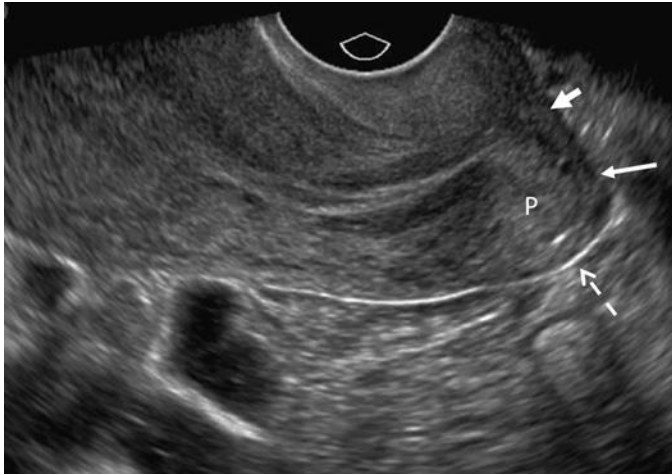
Posterior cul-de-sac/posterior vaginal fornix. Transvaginal sonogram in the sagittal plane through the cervix with bowel in the posterior cul-de-sac. The posterior wall of the vagina (*long arrow*) is seen merging with the posterior lip of the cervix (P). The posterior fornix is demonstrated by a thin echogenic line (*dashed arrow*). The external cervical os is seen at the end of the echogenic endocervical canal (*short, thick arrow*).
